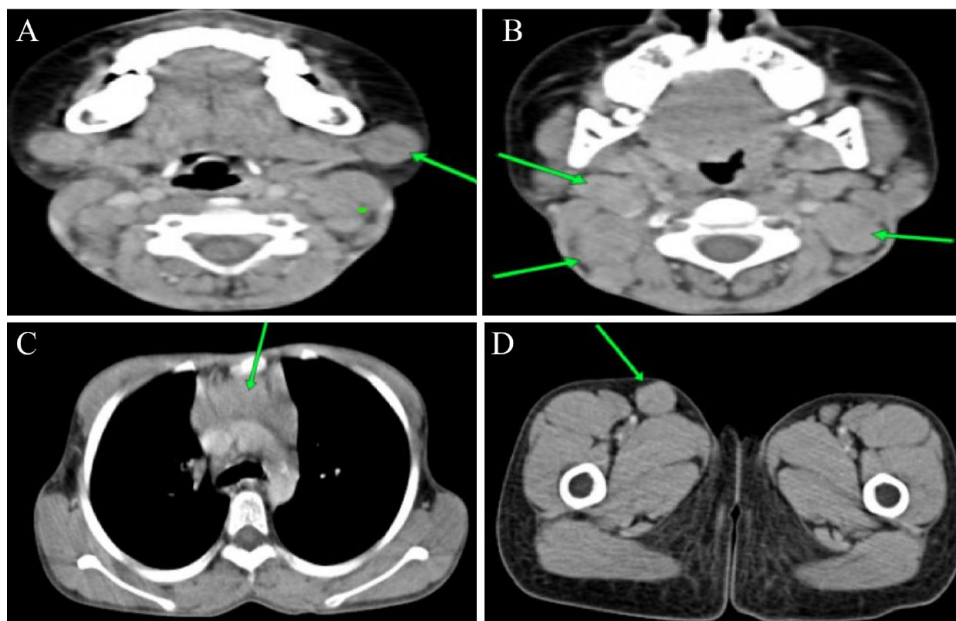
CT images showing generalized lymphadenopathy in the mediastinal, bilateral cervical, and right inguinal regions, (A) Submandibular lymph nodes largest is 1.4 cm, (B) Right anterior and bilateral upper posterior jugular lymph nodes largest is 1.6 cm. (C) Pre-vascular lymphadenopathy, matted nodes measuring $d=2.7\text{ cm} \times 2.2\text{ cm}$, and (D) Right inguinal nodes, measures $d=1.7\text{ cm}$.
